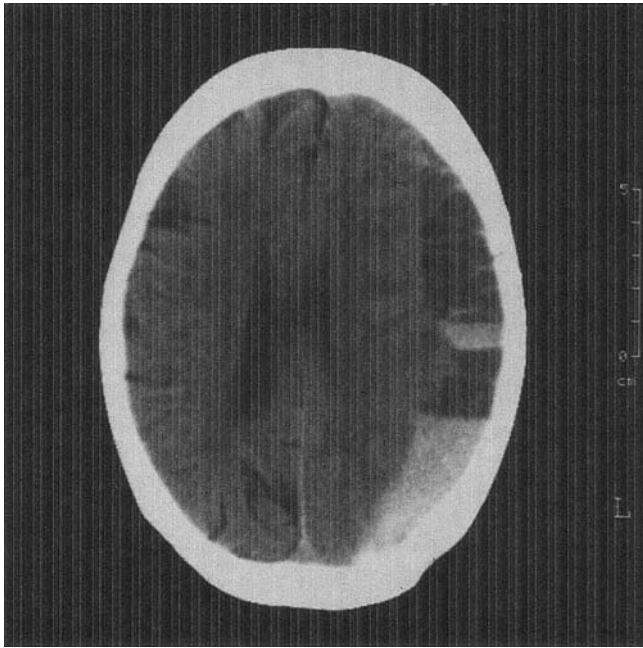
Patient #4. Brain computed tomography scan showing subdural hematoma.
